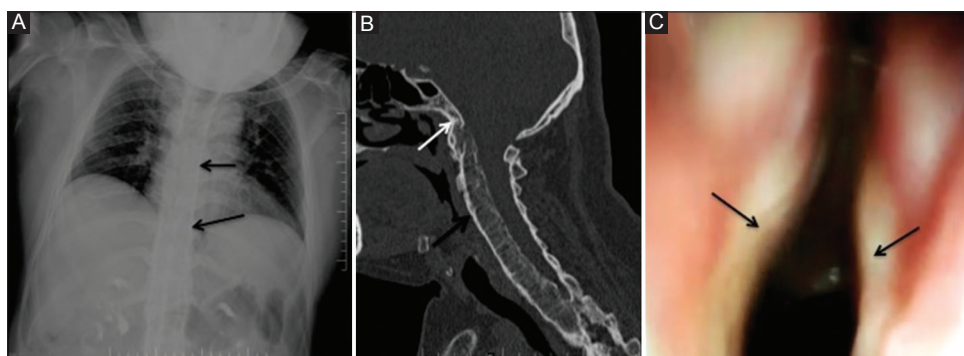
Panel A, chest radiography showing Bamboo spine appearance (black arrows). Panel B, computed tomography of the cervical spine in sagittal view showing fusion of cervical vertebral bodies, ossified longitudinal ligaments (black arrow), and fusion of the anterior arch of the atlas with clivus (white arrow). Panel C, flexible fiberscope view of vocal folds (black arrows)
